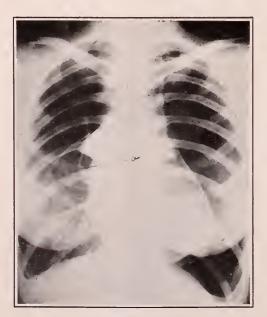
Case VIII, roentgenegram of Jan. 26, 1931, showing degree of bilateral collapse carried by the ambulant patient. Cavities in each upper lobe are satisfactorily closed. At (a) is shown the border of the mobile mediastinum.
